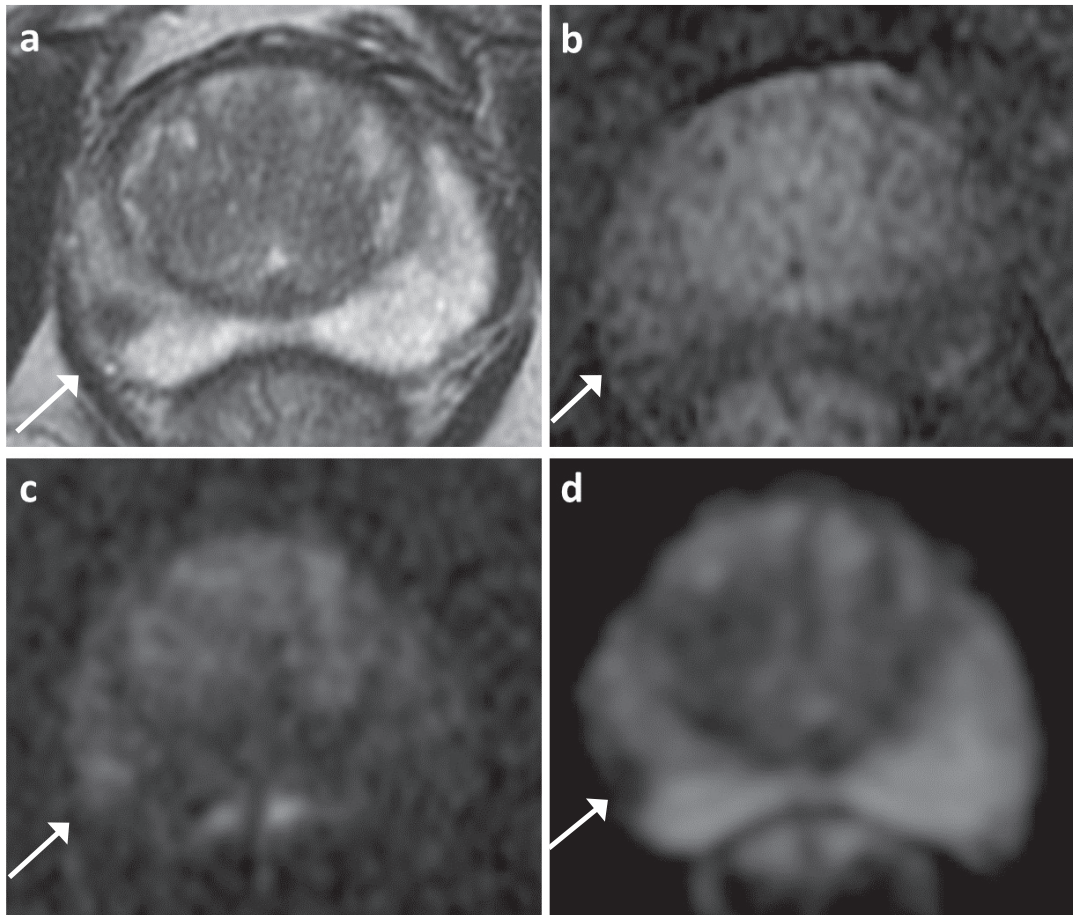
High-quality MRI. (a) T2WI, right peripheral zone posterolateral lesion. (b) at the same level no early enhancement on DCE MRI. (c-d) at the same level hyperintensity on DWI ($b=2000$) and corresponding hypointensity on ADC map. The lesion was classified as PI-RADS 4 (arrow). T2WI, T2-weighted image; DCE, Dynamic Contrast -Enhanced; DWI, Diffusion-weighted image; ADC, Apparent diffusion coefficient.
